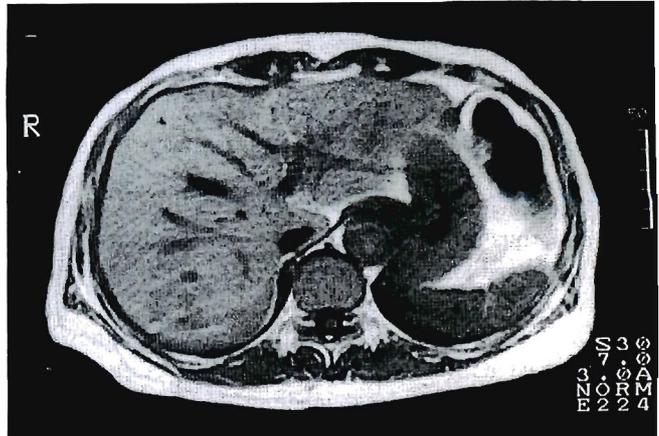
In MRI, the region shows low-intensity on the T1 weighted image (above) and iso-intensity on the T2 weighted image (below) (Case 2).
